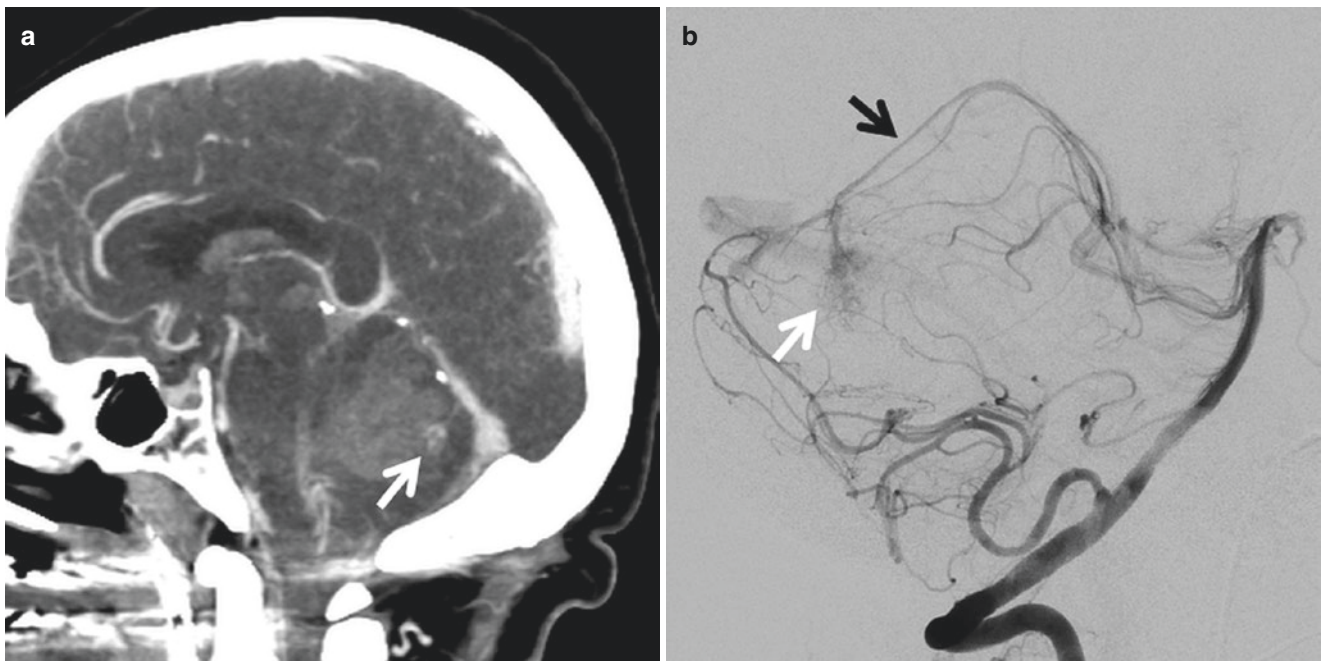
Subtle vermian AVM. Patient presents with cerebellar hemorrhage. (a) Sagittal CTA demonstrates a subtle cluster of abnormal vessels in the vermis (*arrow*). (b) Catheter angiogram lateral view from
